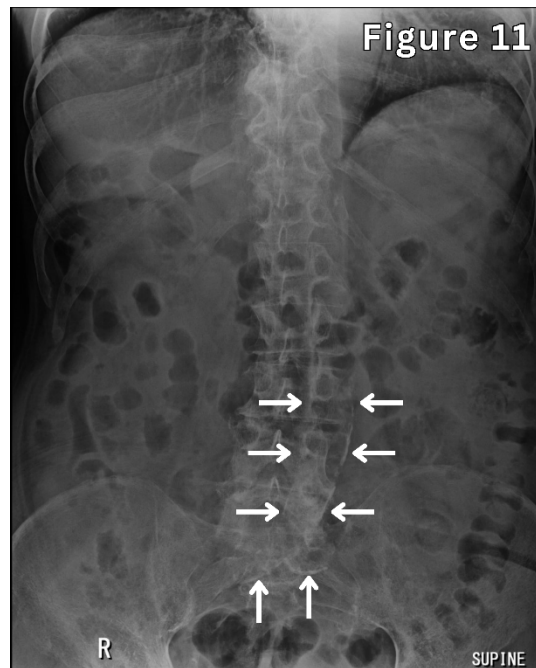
A 79-year-old patient with diabetes, ischaemic heart disease, and peripheral vascular disease demonstrating dense aortoiliac calcification on abdominal X-ray. Note: The aortic bifurcation is low-lying, likely age-related.
